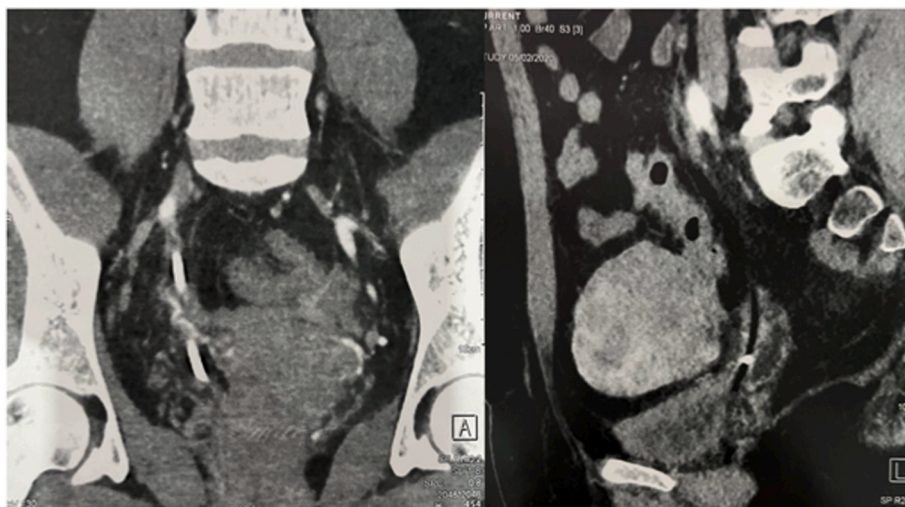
CT coronal sections showed dilation of the right excretory cavities upstream of 2 pelvic and iliac ureteral foreign bodies of 20 and 25 mm in diameter.
